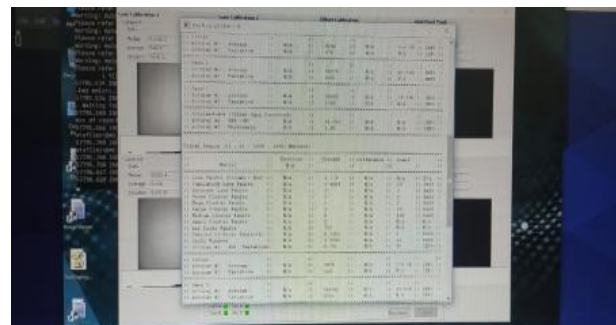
For X-ray tube B
